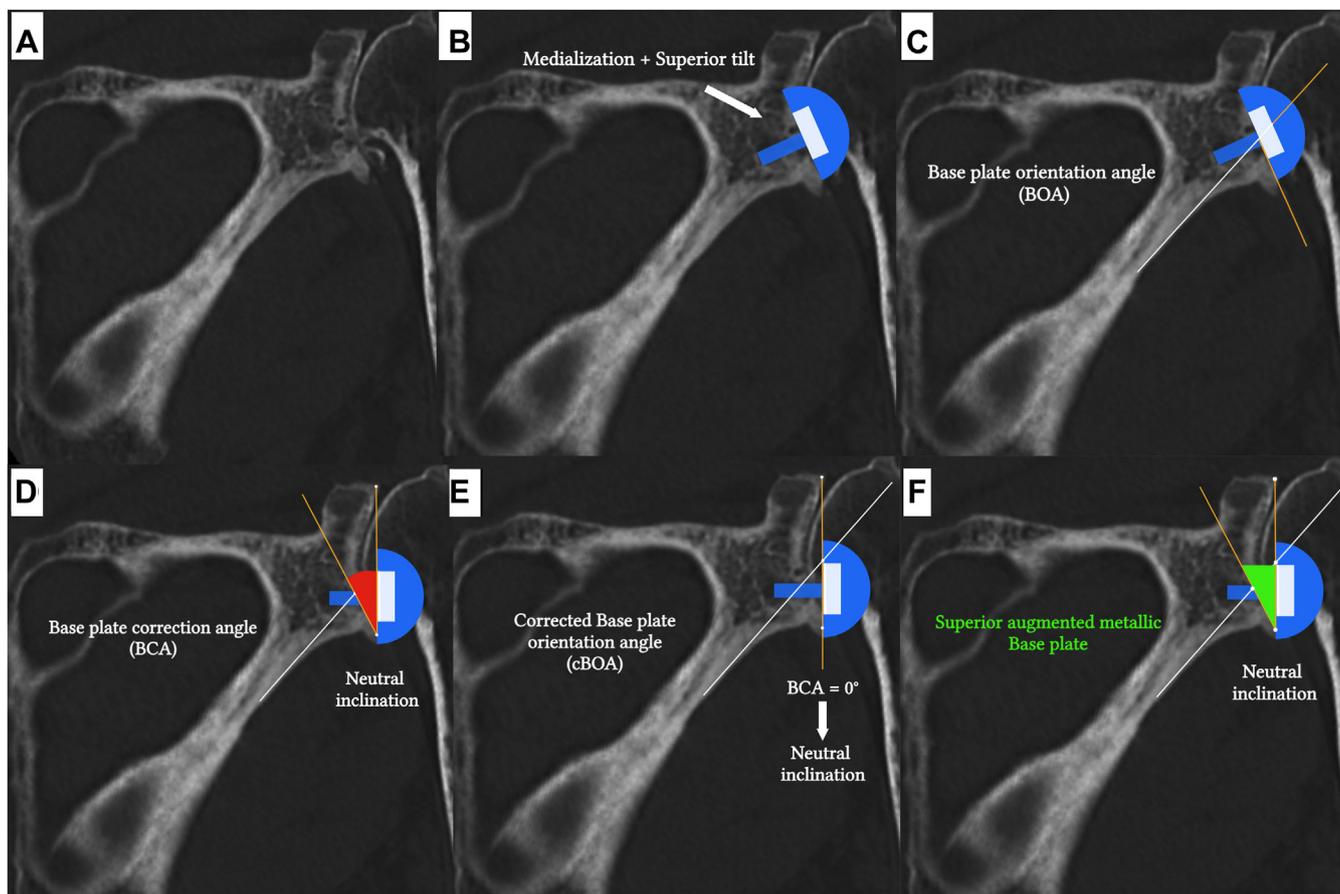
Preoperative 2-dimensional computed tomography of an 82-year-old female patient with cuff tear arthropathy of the left shoulder joint (Hamada and Fukuda stage II)¹⁹ with central glenoid erosion of type E1 (according to Favard)³⁴ (A) Implantation of the base plate without regarding the BOA/BCA results in medialization and superior tilt of the glenoid component (B) Measurement of the BOA (C) Measurement of the BCA to determine the amount of deformity correction required (D) Correction of the BOA results in neutral inclination of the base plate, the $BCA = 0^\circ$ at this point (E) Neutral inclination of the glenoid component obtained using a superior augmented base plate (F). *BCA*, base plate correction angle; *BOA*, base plate orientation.
